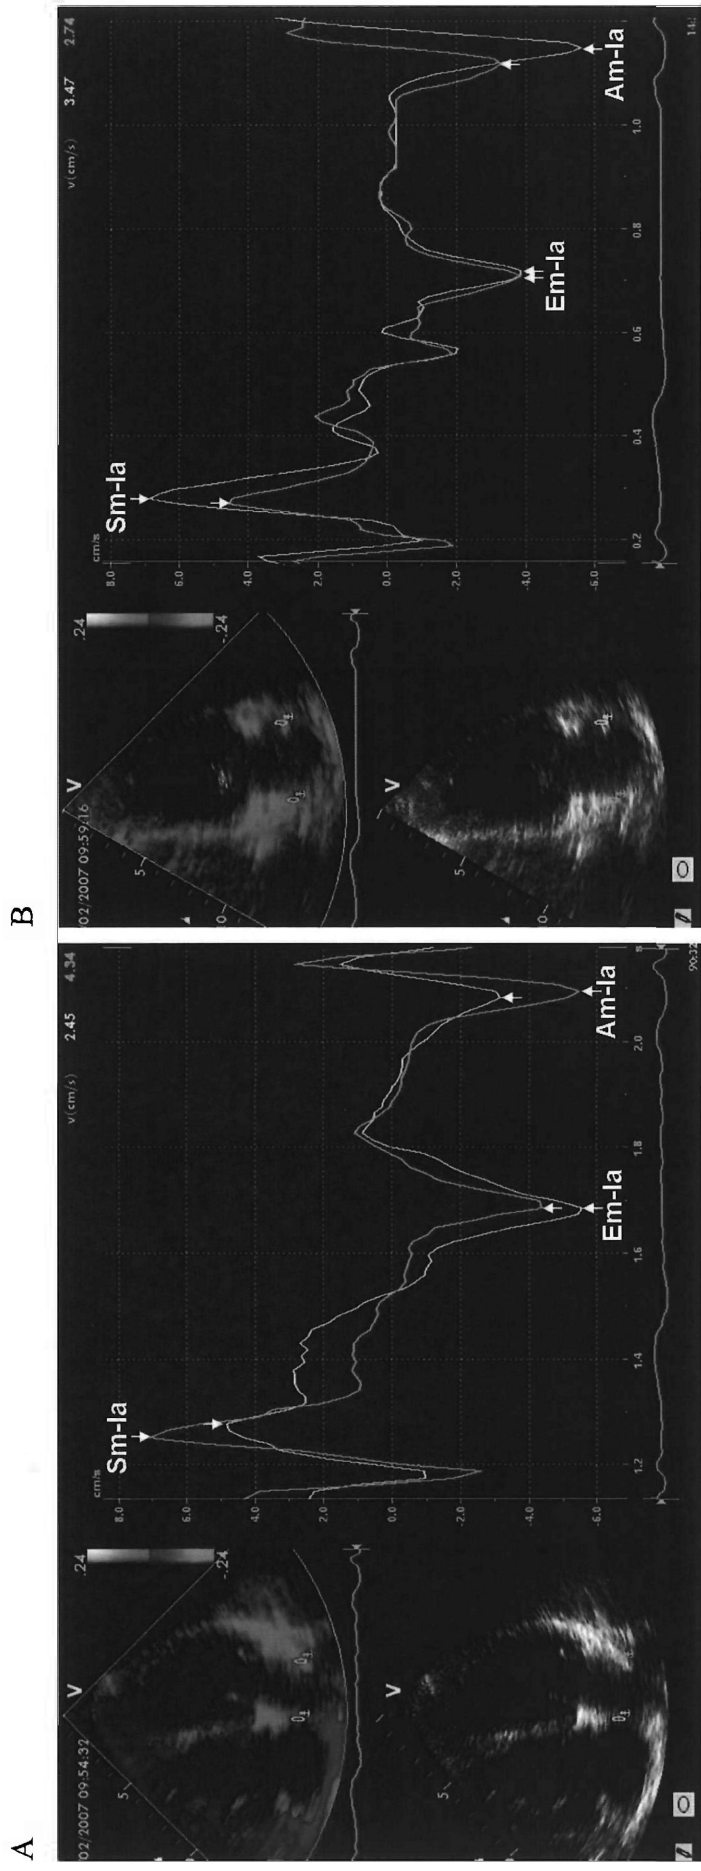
Measurement of tissue velocities of left atrium (LA) in apical 4-chamber (A) and apical 2-chamber (B) views. A sample area of 6 x 2 mm was placed in the mid-level of left atrial walls. The peak systolic (Sm-la), early diastolic (Em-la) and late diastolic (Am-la) velocities were measured.
